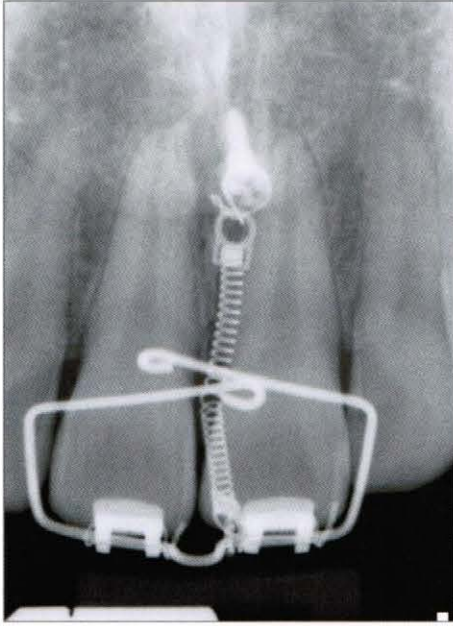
Periapical radiograph after mini-implant insertion. It has been implanted well between the roots of the central incisors. NITI closed coil spring is connected.
